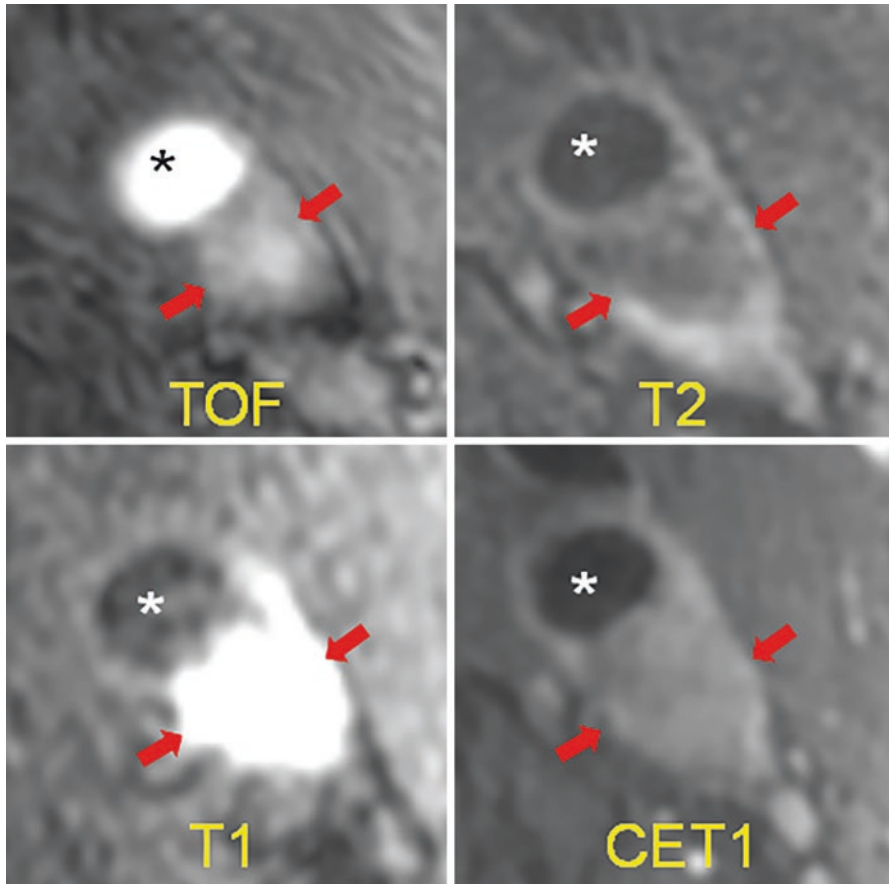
Example of intraplaque hemorrhage on surface coil MRI at 3T. Time of flight (TOF) shows a widely patent lumen (*) with a large plaque associated with positive remodeling, which is T1 hyperintense (arrows). On T2, the lumen (*) is widely patent, and there is T2 hypointensity within the plaque. On MPRAGE, we see the patent lumen (*) with marked T1 hyperintensity in the carotid plaque consistent with hemorrhage. On the contrast-enhanced T1 weighted image (CET1), the plaque is again seen with minimal internal enhancement but robust enhancement of the adventitia. (*J* jugular vein)
